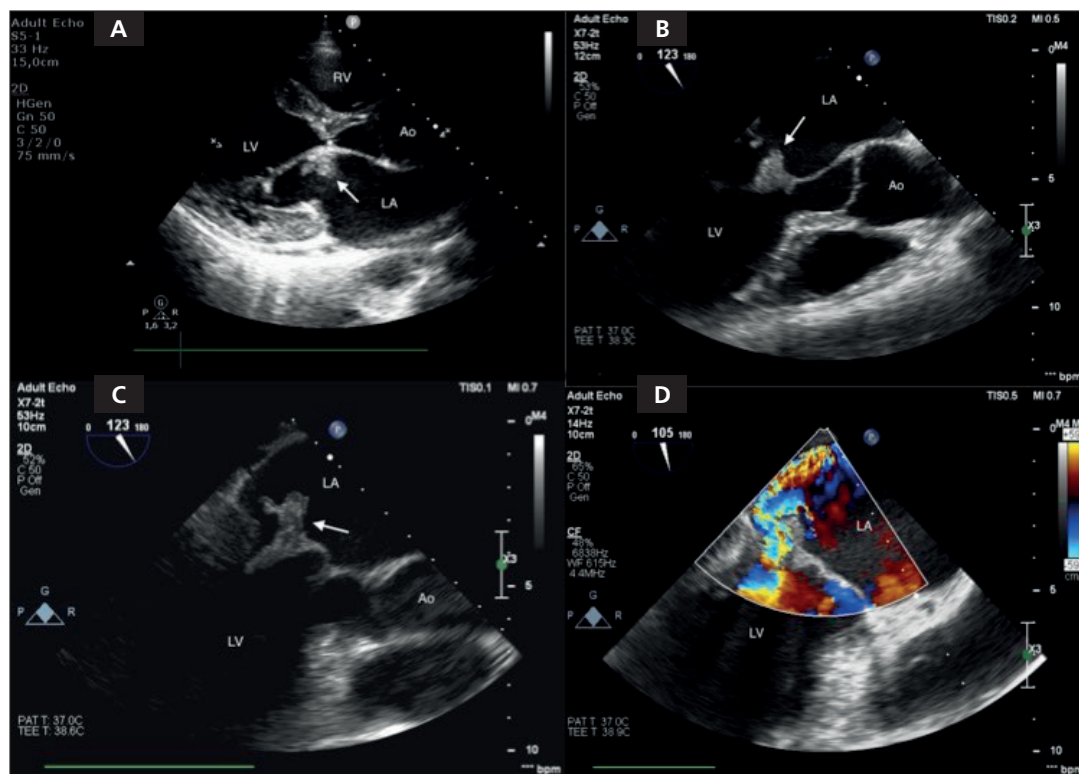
Echocardiography. (A) Transthoracic echocardiography apical three-chamber view and transesophageal echocardiography long-axis view (B) show large vegetation (arrow) on the anterior leaflet of the mitral valve on the atrial side (C). The vegetation measures 20 mm in length (arrow). (D) Color flow image shows severe mitral regurgitation.
